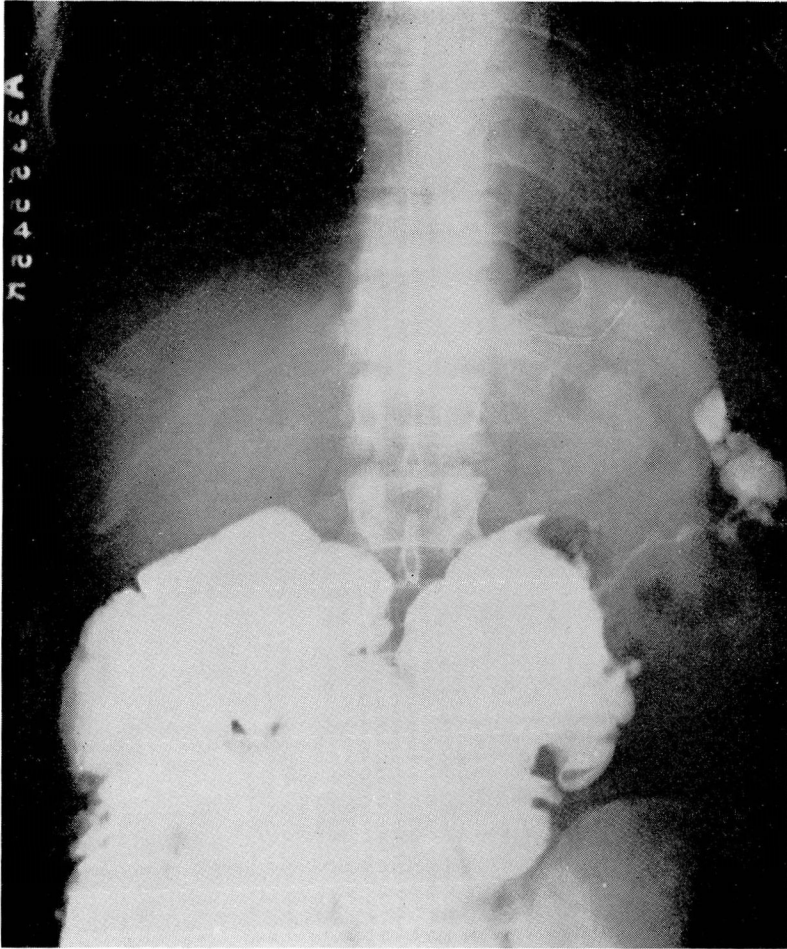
Roentgenogram following a barium enema, again demonstrating the lesion near the splenic flexure.
